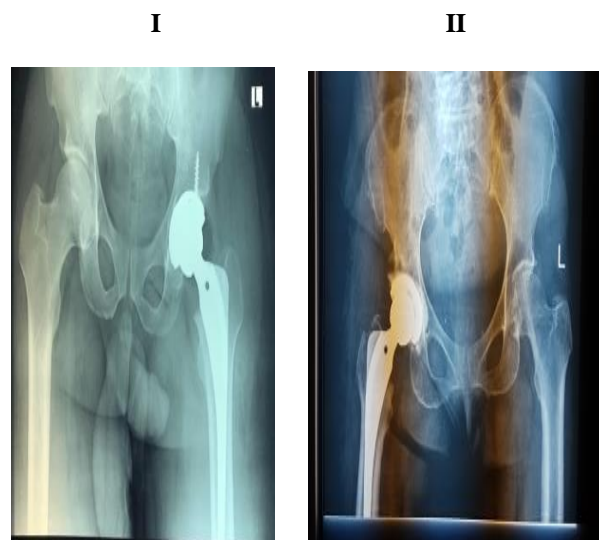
Post-operative x-rays: I cementless left primary total hip replacement, II cemented cup and cementless stem total hip replacement.
